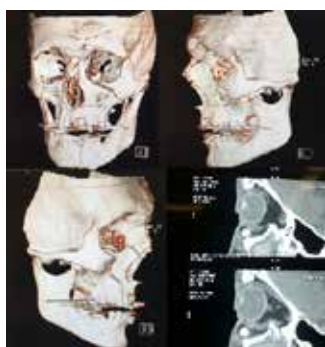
Preoperative CT scan. Case 3.
